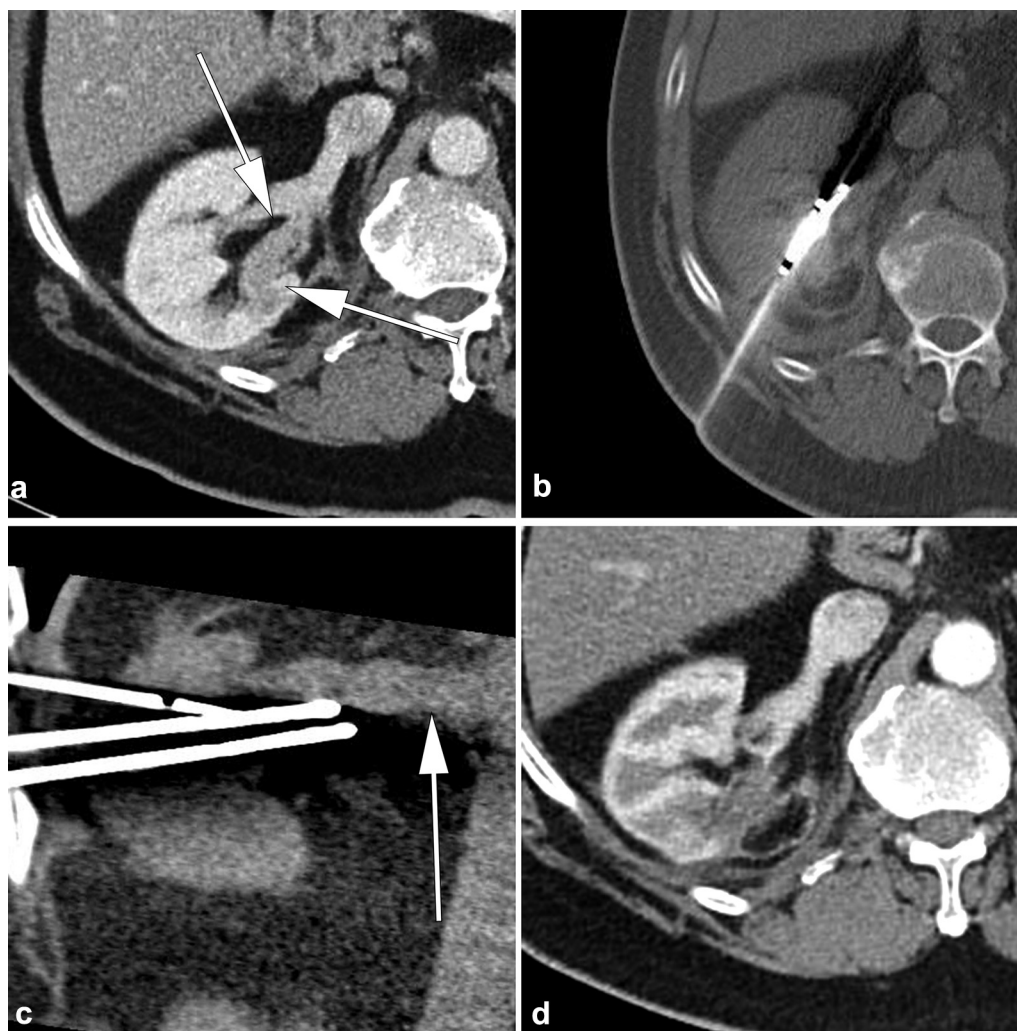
Patient with prior right PN for a grade 2 of 4 clear cell RCC. (a) Axial CT image with intravenous contrast administration shows a solid tumor extending into a posterior segmental renal vein (arrows). (b) CT image obtained during cryoablation shows 2 of 3 cryoprobes cannulating the tumor in the renal vein. (c) Oblique coronal reconstructed CT image shows the proximity of the cryoprobes to the main right renal vein (arrow). (d) Axial CT image with intravenous contrast administration obtained 17 months after treatment shows no recurrence of RCC.
